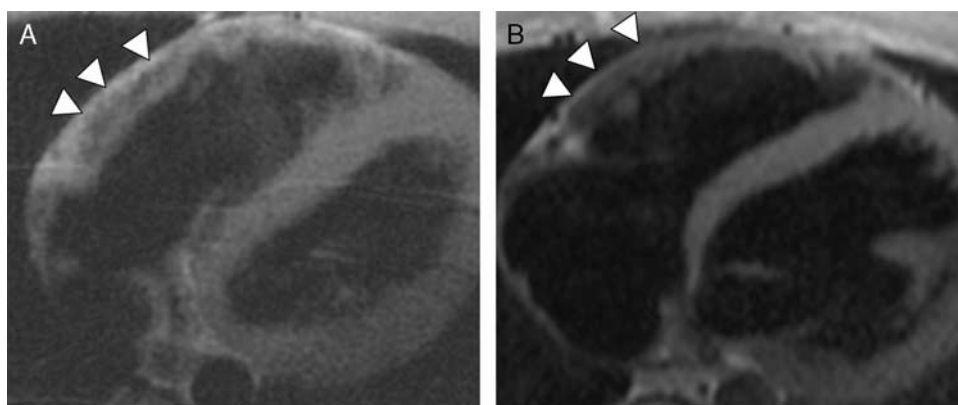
Fat infiltration in the RV wall in classical RV-predominant ARVC/D. A, Axial dark blood image from a cardiac CT obtained in a 17-year-old boy with ARVC/D. There is irregular high signal along the epicardial surface of the basilar to mid RV anterior wall due to fat infiltration (arrowheads). B, Normal RV wall for comparison showing a smooth epicardial contour (arrowheads).
